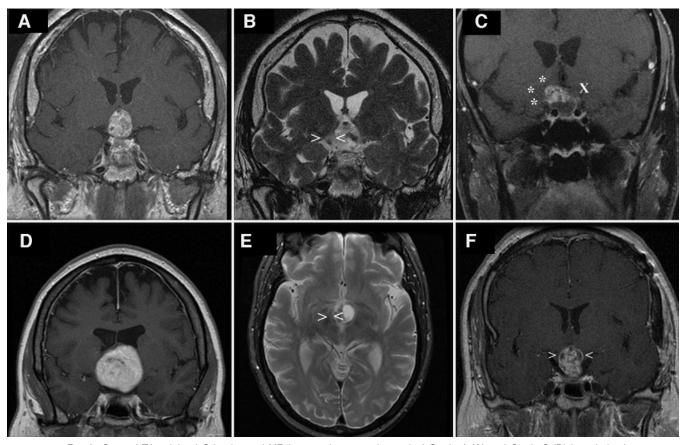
Coronal T1-weighted Gd-enhanced MR images demonstrating typical Grade 1 (A) and Grade 2 (D) hypothalamic compression. Coronal (B) and axial (E) T2-weighted images of typical peritumoral hypothalamic T2 change (between the *open triangles*). Coronal T1-weighted Gd-enhanced images demonstrating irregular contrast enhancement at the right (asterisks) and left (X) hypothalamic border (C), and in contrast a smooth enhancement (F between the *open triangles*).
